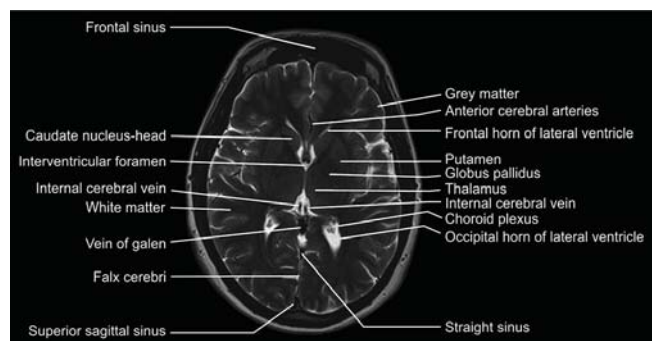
MRI Transverse view of brain
